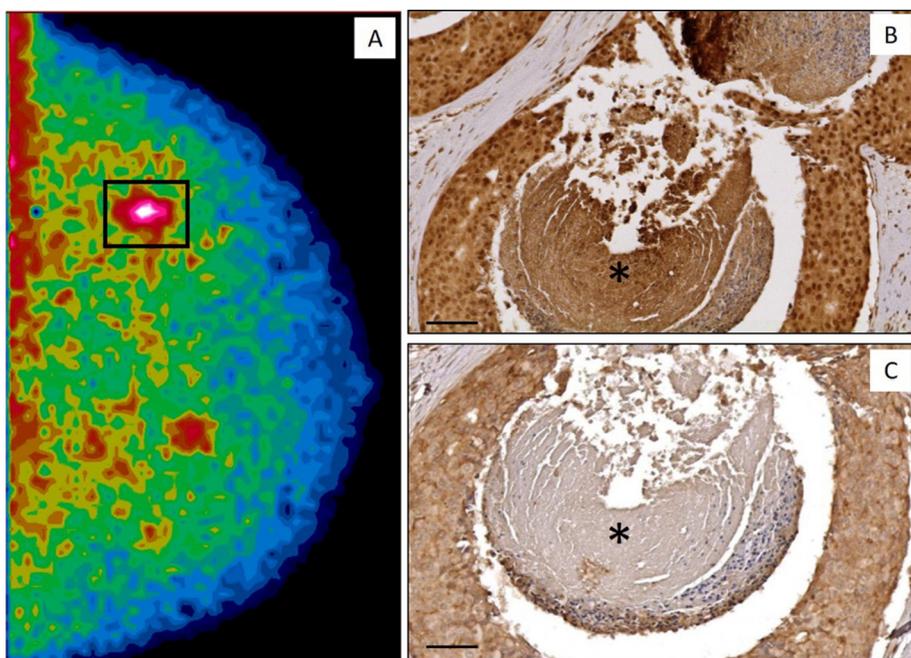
Sestamibi uptake in breast lesions with BOLCS. A) ^{99m}Tc sestamibi high-resolution SPECT image. Square highlight a small breast lesions with high uptake of sestamibi (SUV max 150 SUV average 100.7). B) Image displays several RUNX2-positive breast cancer cells next to microcalcification (asterisk) in the lesions detected by ^{99m}Tc sestamibi high-resolution SPECT. C) Image shows numerous RANKL-positive breast cancer cells close to microcalcification (asterisk) in the lesions detected by ^{99m}Tc sestamibi high-resolution SPECT. Scale bars represent 40 μm .
